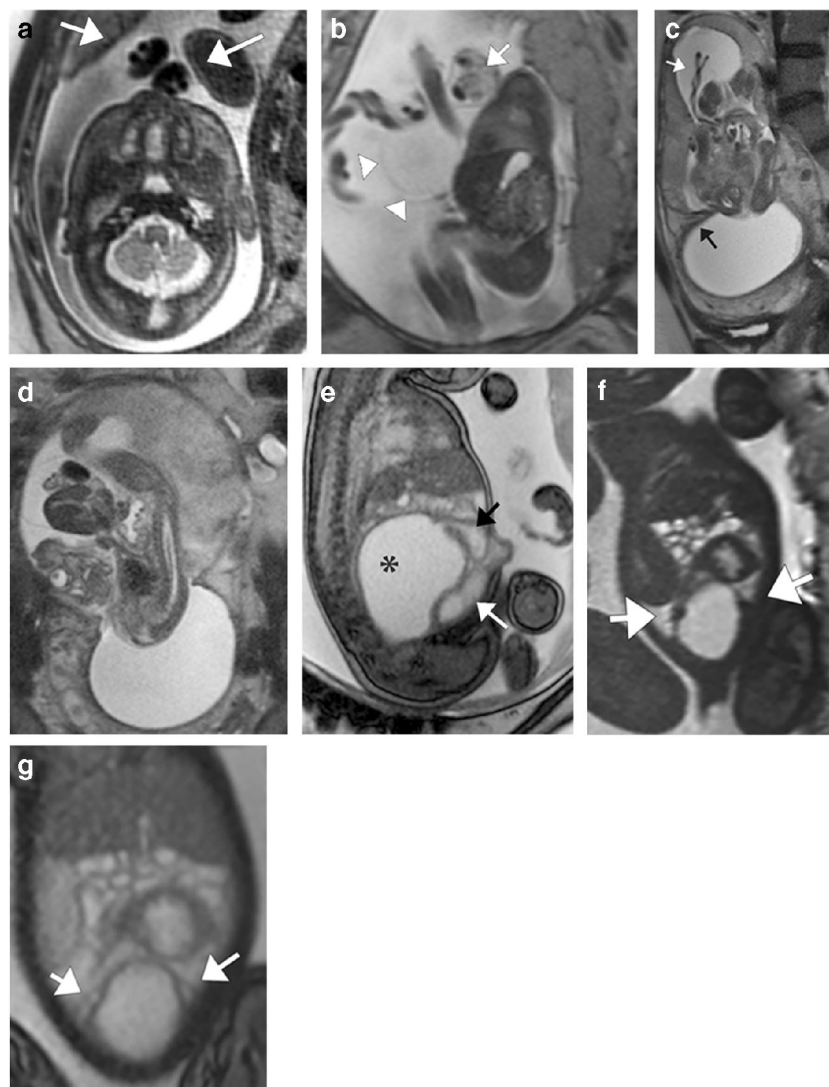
The umbilical cord. a The three-vessel cord comprises two umbilical arteries and a vein, in a configuration that at MRI resembles a smiling face, as seen in this single-shot turbo spin-echo (SSTSE) cross-sectional image through the cord in a third-trimester gestation (arrows). b Cord masses are unusual; the sagittal SSTSE image in this 22-week fetus demonstrates the relatively common cord cyst (arrowheads) and the unusual cord hemangioma (arrow). c, d Sagittal (c) and coronal (d) SSTSE images through the pelvis in a woman carrying an 18-week fetus with limb-body wall defect. The fetus affected with this pathology might have short or unwound/underwound umbilical cord, as in this case (two vessels, underwound cord; white arrow in c). The placenta implanted in a thick uterine synechia (black arrow in c; note the maternal bladder at the lower edge of the image). The fetus, which had
